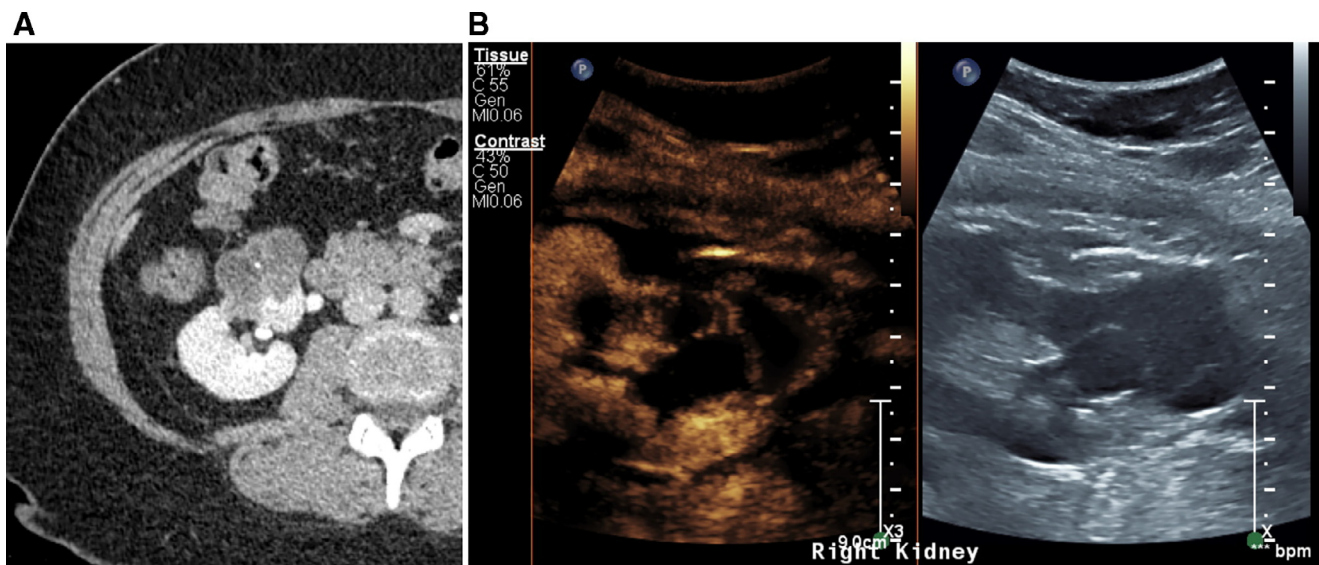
A 46-year-old female with a complex right-sided renal cyst. (a) Portal venous phase contrast-enhanced CT scan shows a 4.7 × 3.4 cm multi-loculated lesion. Some of the locules are of high attenuation, in keeping with haemorrhage. The septations are thin, with fine calcification. (b) CEUS reveals several (≥ 4) thin septa without nodularity. The lesion was categorized as IIF and has been stable on observation for the past 18 months.
